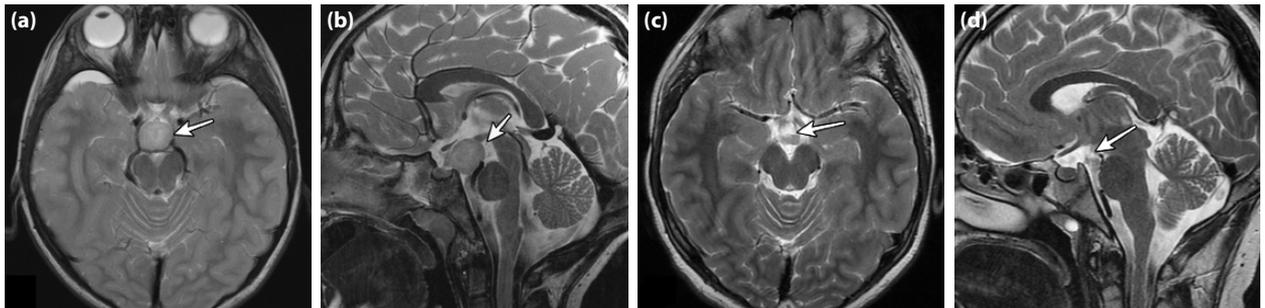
(a) Axial section T2 weighted MRI of a patient with type 1 HH (arrow). (b) Sagittal section T2 weighted MRI of the same patient (arrow). (c) Axial section T2 weighted MRI of the patient after disconnection surgery through pterional route. Arrow designates disconnection plane. (d) Sagittal section T2 weighted MRI of the same patient after disconnection surgery. Arrow designates the disconnection plane.
